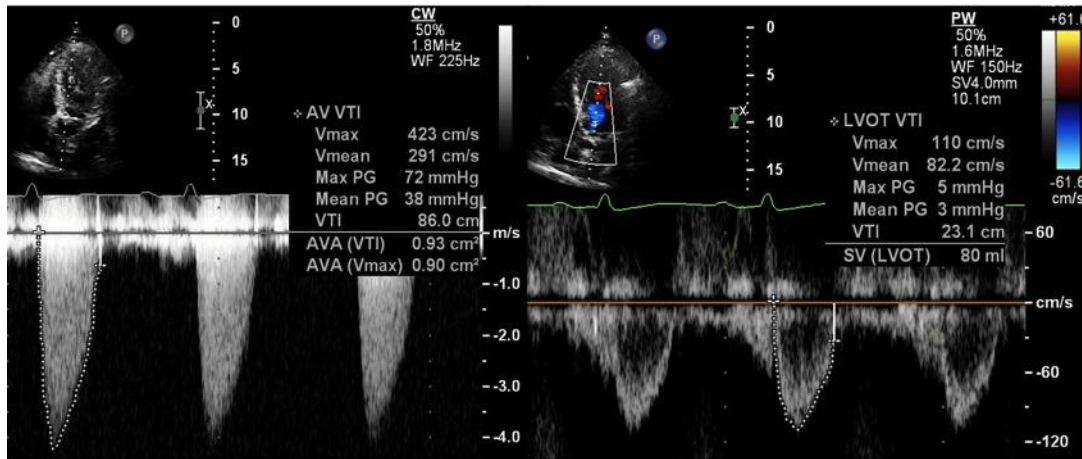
An example of continuous-wave Doppler through the aortic valve (left) with peak and mean pressure gradients displayed, and pulsed-wave Doppler through the LVOT (right), used for the calculation of Aortic Valve Area.
